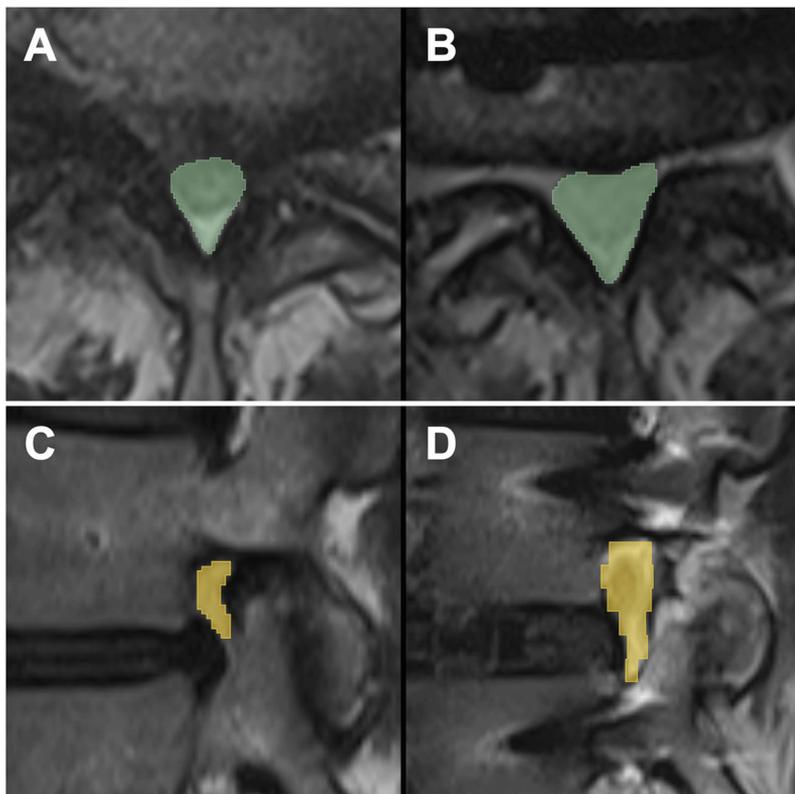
Representative contours of the CC and NF on T2-weighted MRI used for area measurements. (A) Sample contour of the CC at mid disc level in the axial plane pre-LLIF demonstrating moderate (grade II) stenosis. (B) Post-operative CC contour demonstrating increased area with no stenosis (grade 0). (C) Pre-LLIF contour of (right) NF with severe (grade III) stenosis on sagittal view. (D) Contour of the same NF with improved area and stenosis (grade I) after decompression.
